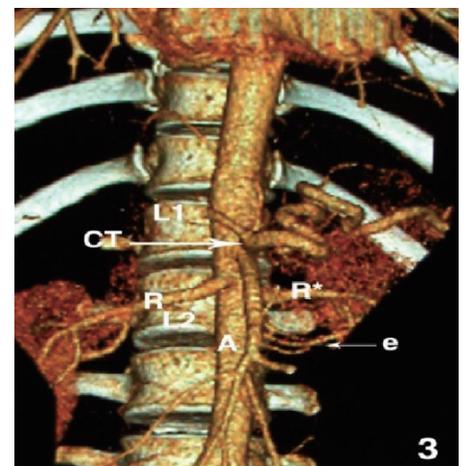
3-D MDCT angiography shows celiac trunk (CT), right renal artery (R) origin at the upper level of L2, left renal artery (R*) origin at the middle level of L2. Note that the extra left renal artery (e) on the left side arises from the aorta (A) at the lower L2 level and enters into the kidney outside the hilum..
